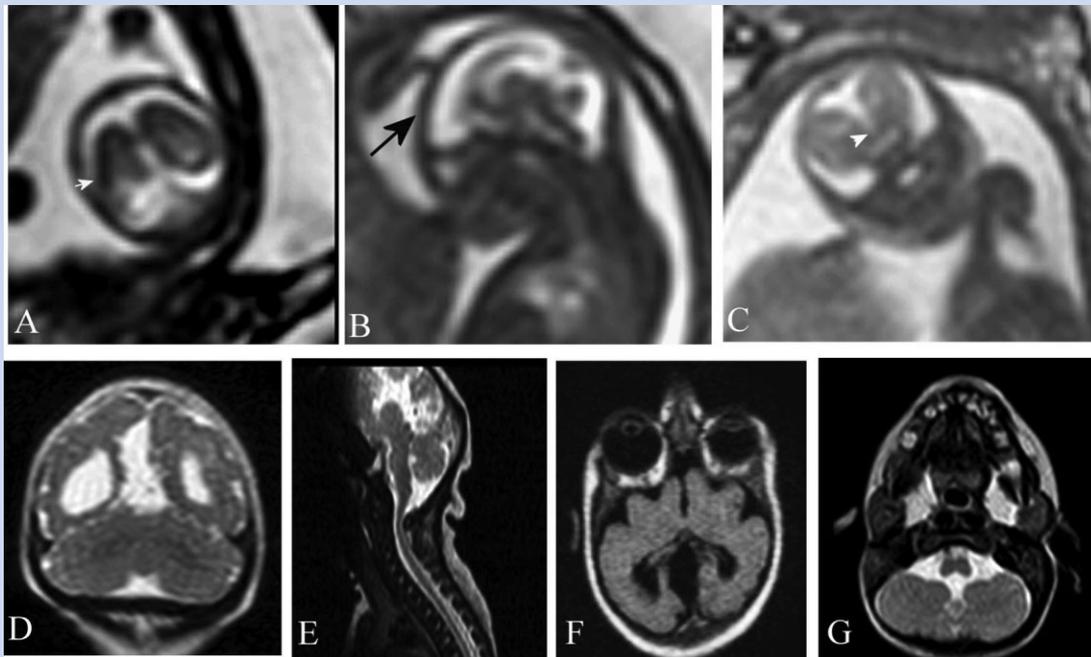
Fetal MRI brain of Patient 2 at 20 gestational weeks. A: Coronal view showing poor developed cortex [white arrow] and the interhemispheric cyst. B: Sagittal T2-weighted bSSFP shows interhemispheric cyst [black arrow], hypogenesis of corpus callosum, enlarged cisterna magna, underdeveloped pons with flattened pontine and small sized cerebellum but of proportionate size to the small cerebral hemispheres. C: Axial view showing proportionately small cerebellum [white arrow head]. Postnatal brain MRI of Patient 2. D: Coronal view showing extremely simplified gyral pattern, thin cerebral cortex, and interhemispheric cyst. E: Sagittal view showing agenesis of corpus callosum but proportionately affected cerebellum vermis and pons. F: Axial view showing abnormal gyral pattern and too shallow sulci. G: Proportionate small cerebellum and brain stem.
